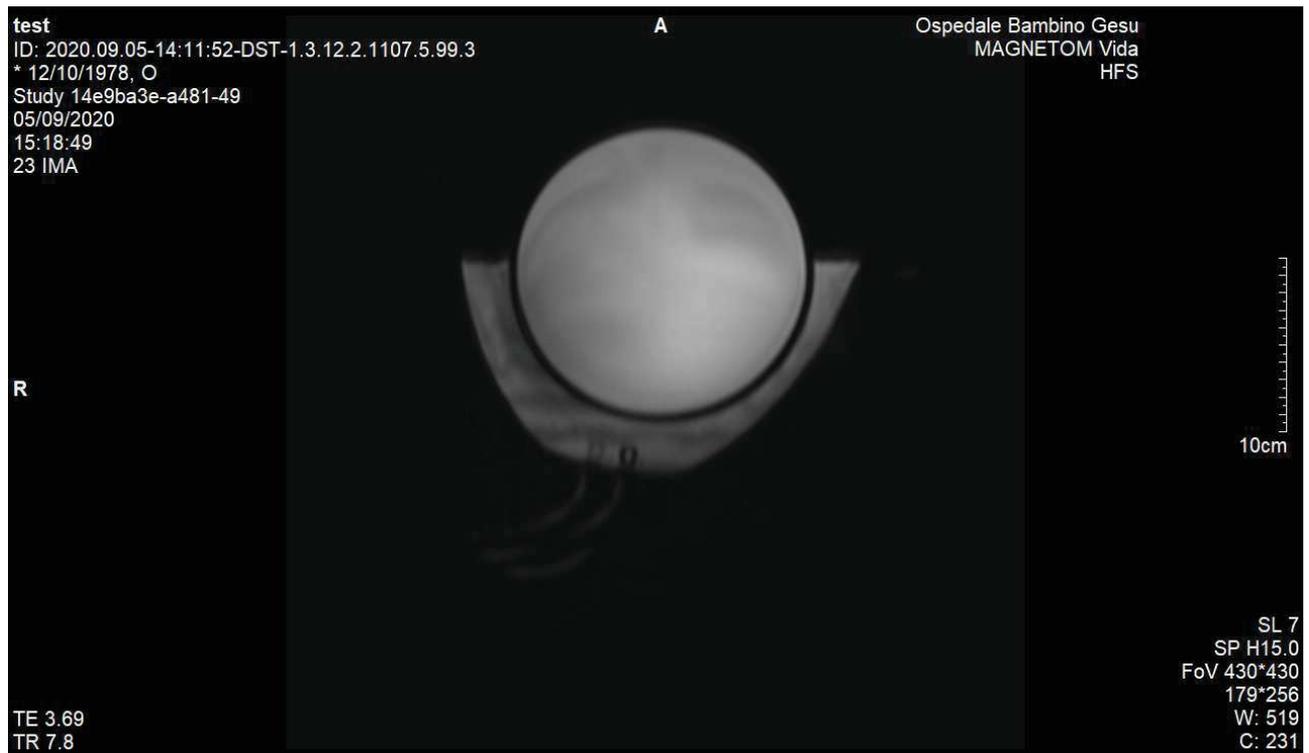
MRI image scanned
